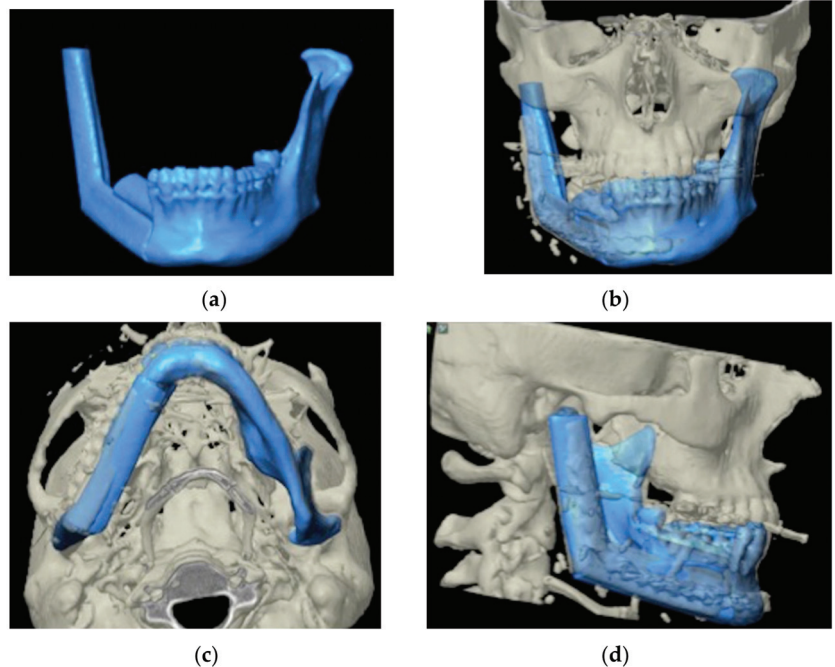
(a–d): Preoperative images of surgical planning and postoperative CT images are overlapped and positional discrepancies are measured.
